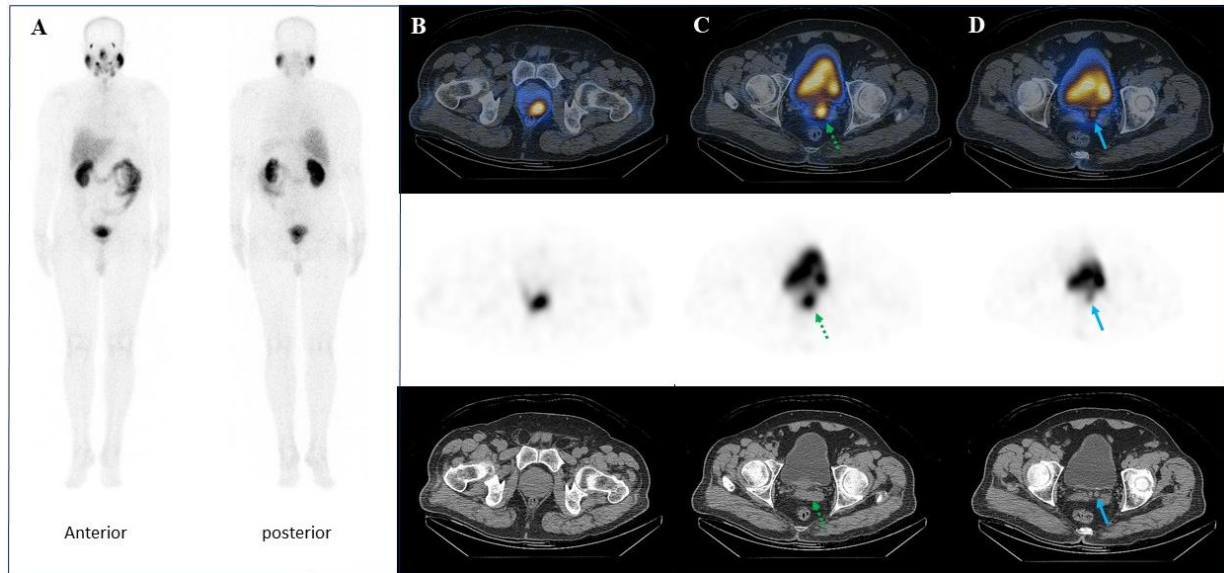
[$^{99\text{m}}\text{Tc}$]Tc-PSMA SPECT/CT images demonstrating findings consistent with PET/CT, including uptake in the primary prostate tumor (B), left seminal vesicle base (C, dotted arrows), and vas deferens ampulla (D, arrows)
